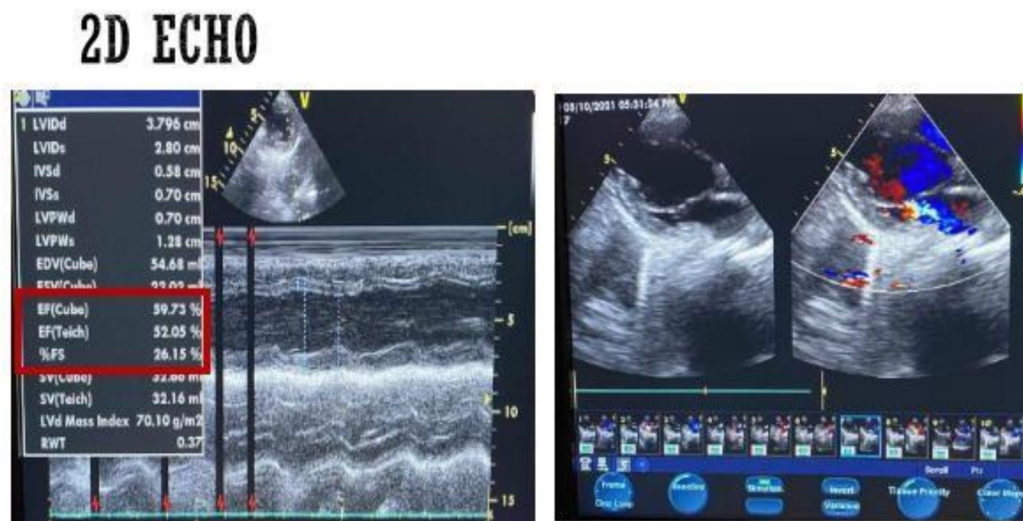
2D-Echocardiography
